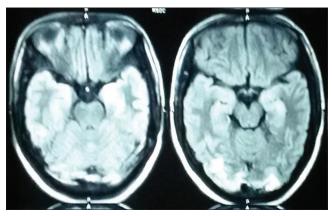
Hyperintense signal in occipital and parietal region in MRI
